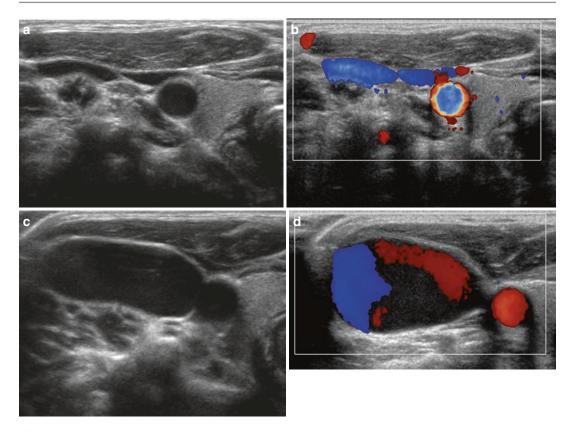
Jugular varix. Grey scale and colour Doppler ultrasound images of the jugular vein (a–d) demonstrates marked dilatation with Valsalva consistent with varix/ectasia in a child presenting with a neck mass on crying
